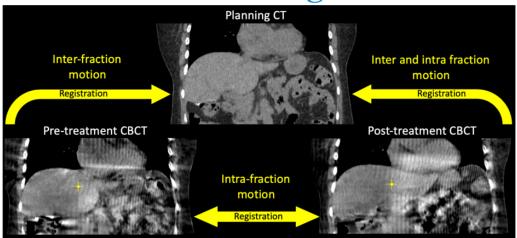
shows relations between planning CT, pre-treatment CBC1 (during setup) and post-treatment CBCT that could be used to measure motion from inter-fraction, intra-fraction and both. Rigid registration was used to determine intra-fraction motion by computing iso-center point shifts (yellow crosshair) between pre/post CBCTs.
